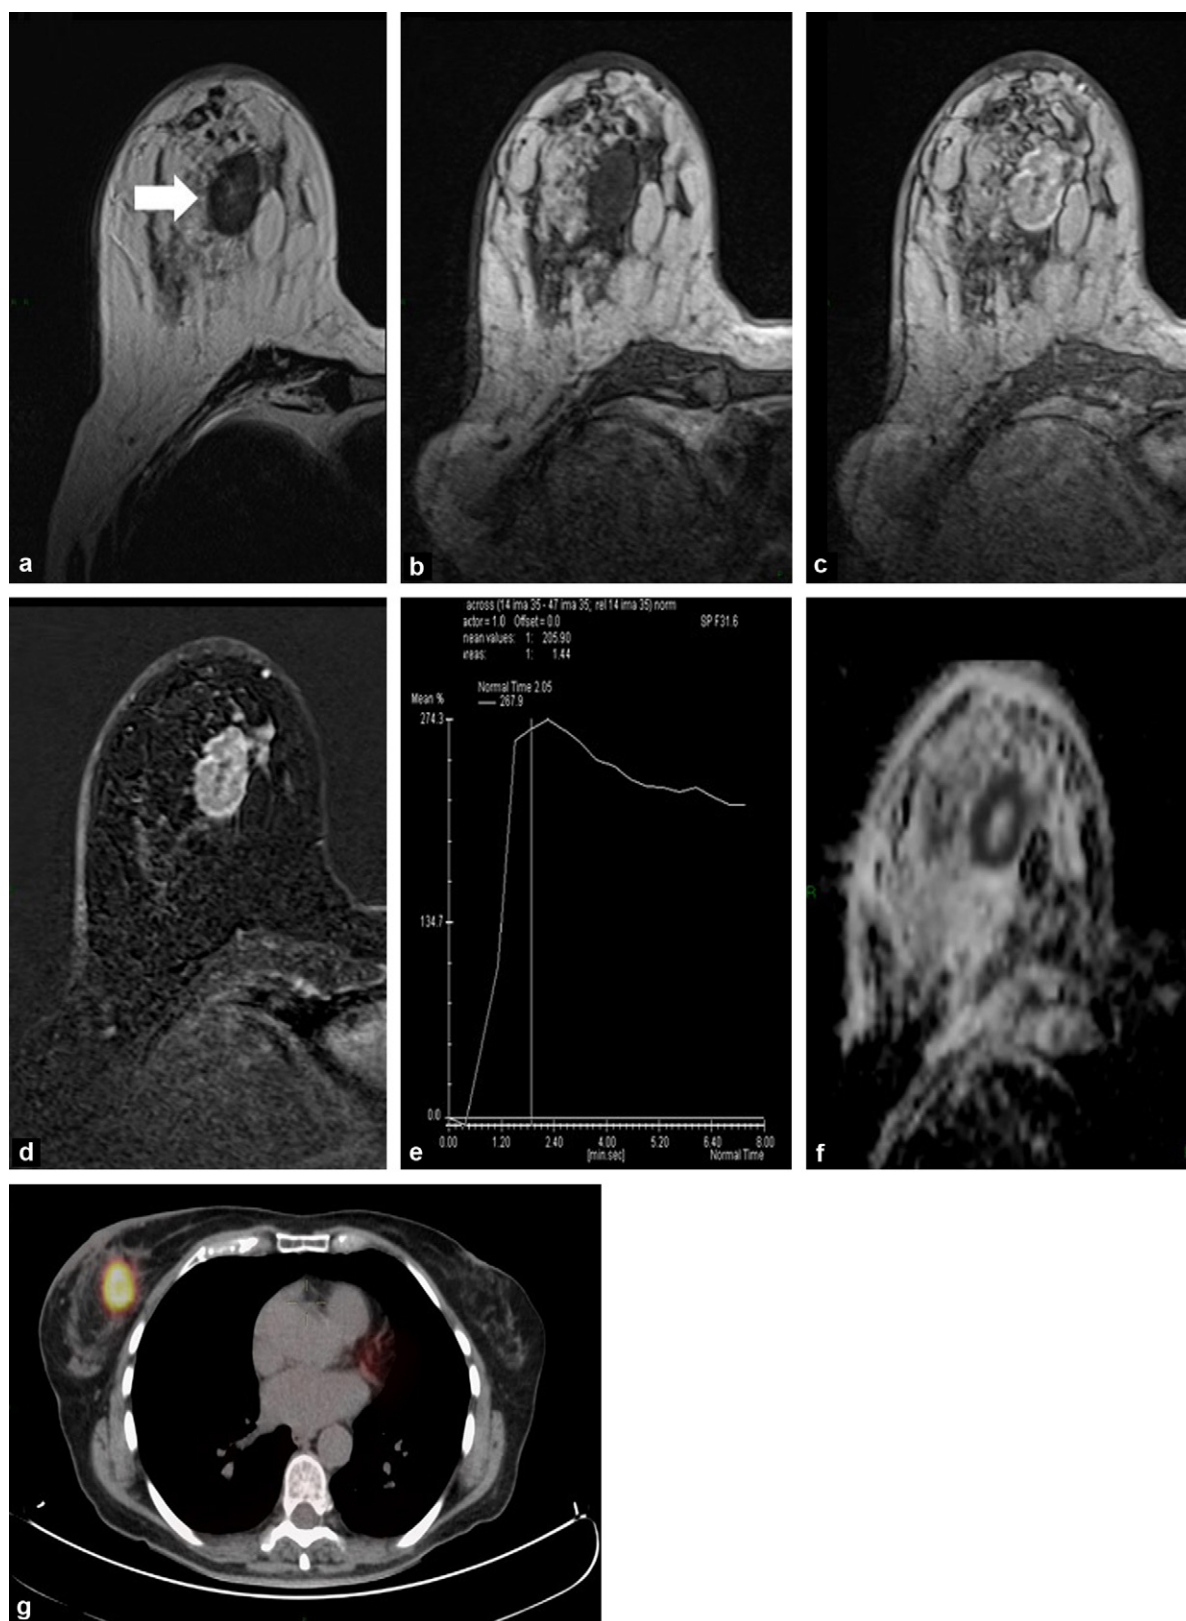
MRI and PET-CT monitoring of a patient treated for infiltrating ductal carcinoma (SBR grade III, HER2 3+, RE negative, Rp negative) of the right breast, clinically PEV 3, treated by neoadjuvant chemotherapy. Before treatment, the MRI morphological analysis showed an oval, circumscribed mass (arrow), with annular enhancement and central necrosis (a: T2, b: T1, c: injected T1, and d: subtracted injected T1). Still before treatment, the tumoural enhancement kinetics show early, intense contrast uptake (267% at 2 minutes) followed by a washout (type 3) (e). The diffusion sequence (f) shows restriction of the diffusion with an ADC measured at $1.0 \times 10^{-3} \text{ mm}^2/\text{s}$. In PET-CT with ^{18}F FDG (g), hypermetabolism is seen in the tumour with an SUV measured as 12.
